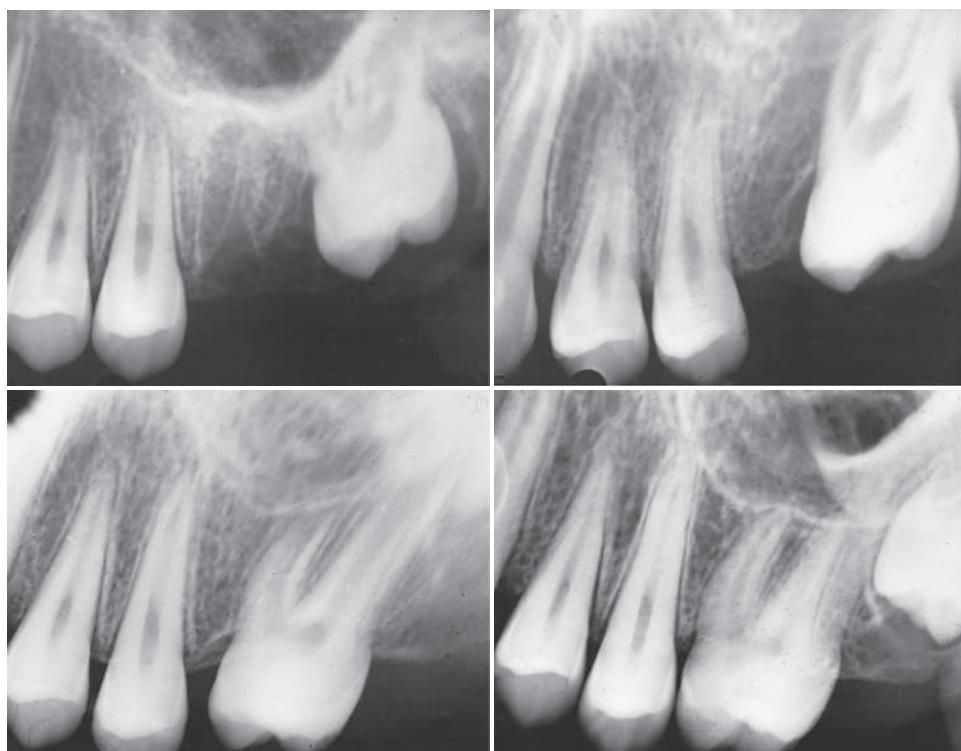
Radiographs taken at 6-month intervals after a maxillary first permanent molar was lost before the eruption of the second permanent molar.
